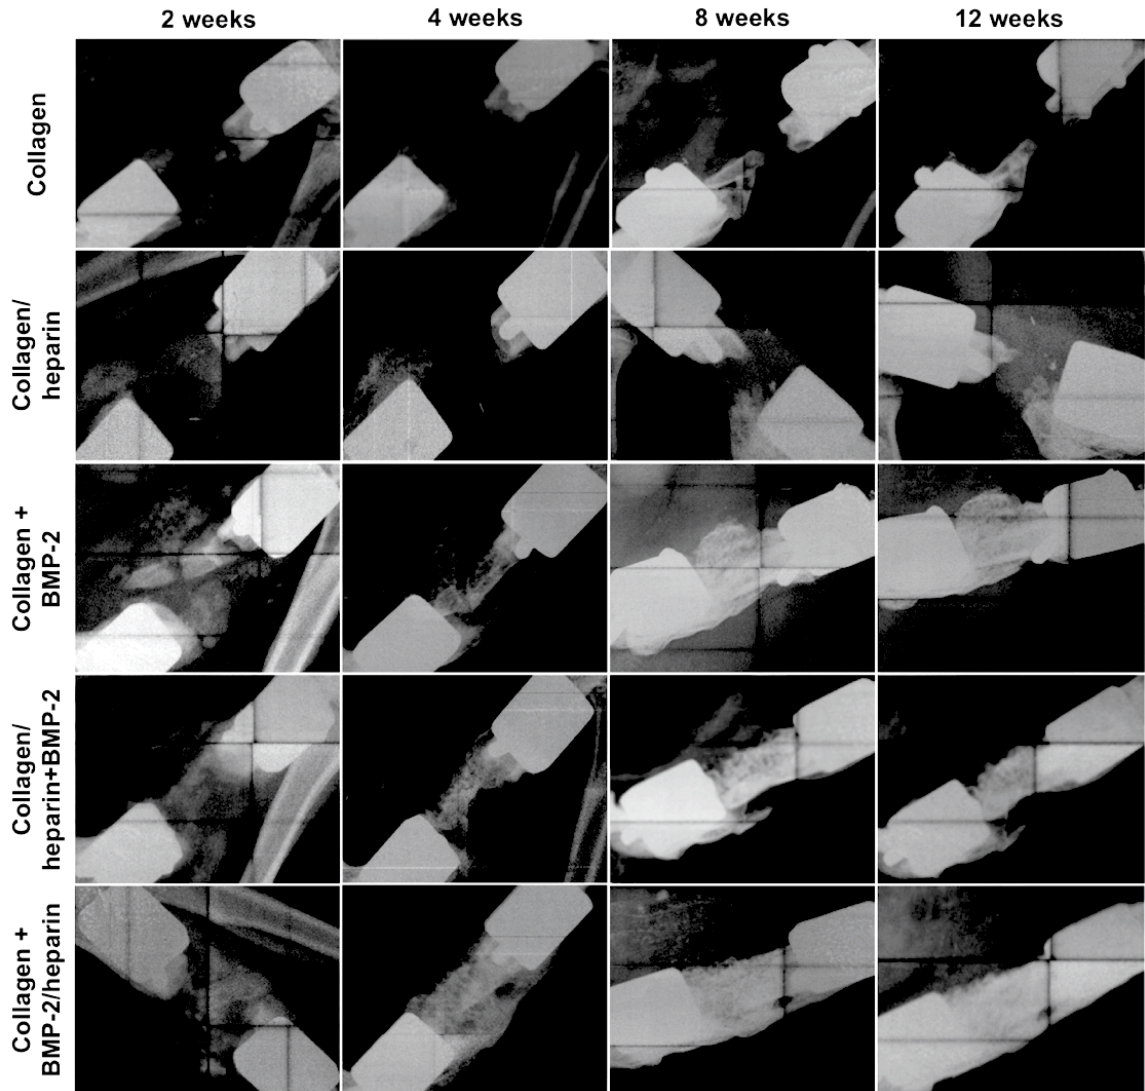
Representative *in vivo* 2D x-ray images of defect sites obtained at 2, 4, 8, and 12 weeks post-op.
